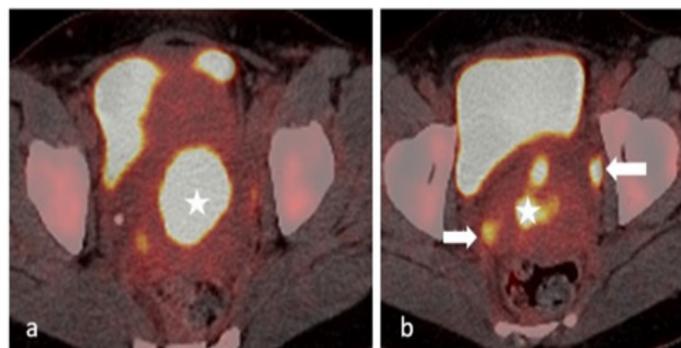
PET scan (a, b) in the same patient shows an intense FDG uptake of the mass (asterisks) and of a left iliac lymph node (arrow). Axial CT scan (c) shows the IUD, which is the key of the diagnoses.
